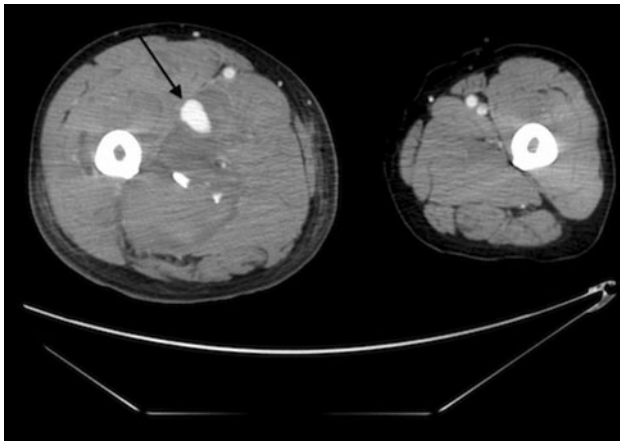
Contrast-enhanced computed tomography (CT) scan 21 days after the trauma revealed a pseudoaneurysm and surrounding hematoma in the right thigh (*arrow*)
